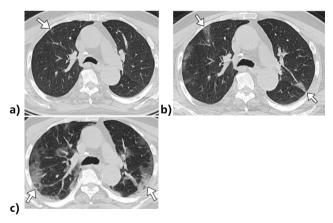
A 76-year-old man with a positive RT-PCR test. He died after 16 days of treatment in the intensive care unit. a) Axial lung window of first non-contrast chest CT shows peripheral localized nodular ground glass opacity (GGO) in the upper lobe of the right lung (arrow). CT-SS₁ =2; neutrophil/ lymphocyte ratio (NLR)₁: 2.25. b) Axial lung window of second chest CT shows bilateral peripheral localized GGOs (arrows). CT-SS₂ =9; NLR₂:3.19. c) Axial lung window of third chest CT shows increased bilateral peripheral localized GGOs (arrows). CT-SS₃ =20; NLR₃:24.58
